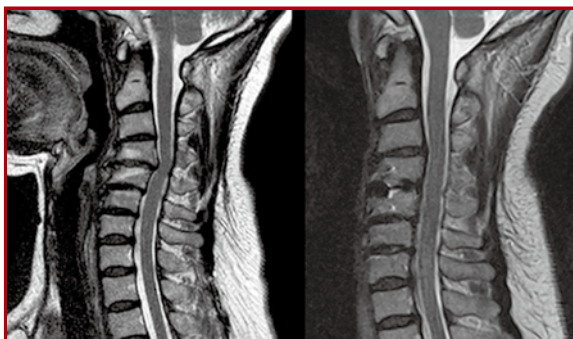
A 55-year-old woman presented with neck pain and right radiculopathy. MRI C-spine (left) showed focal kyphosis at C4/5 with cervical spondylosis and bulging discs. Her symptoms resolved after a single level ACDF. Postop MRI (right) showed the reduction of focal cervical kyphosis. (Personal collection)
